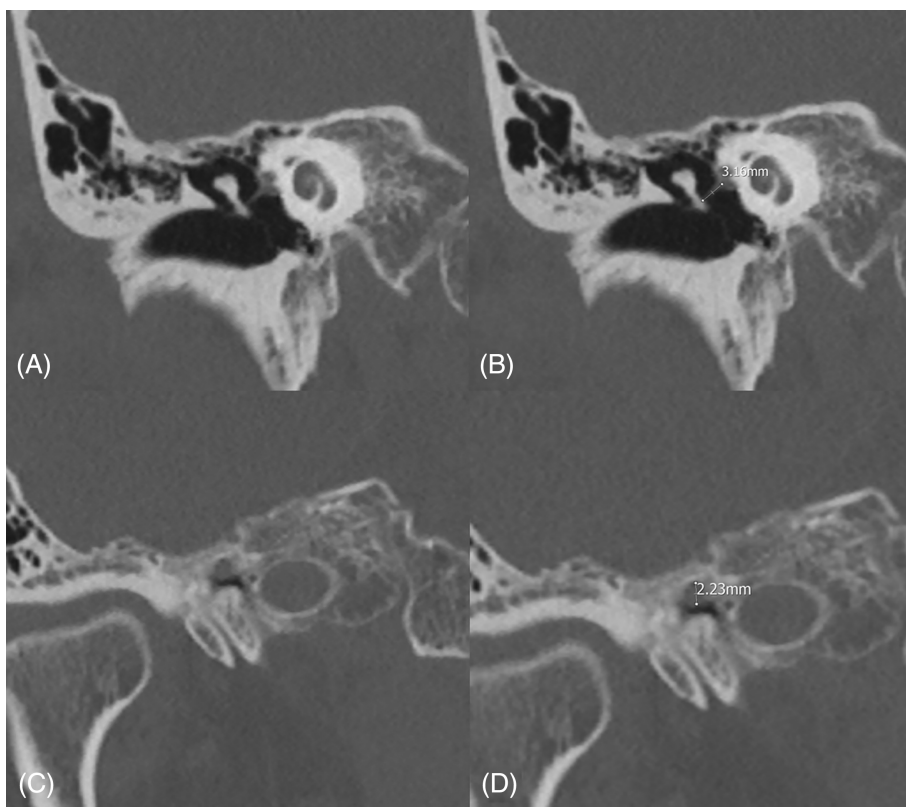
Tensor tympani measurement. Right temporal bone CT in coronal view. (A) The tensor tympani muscle was located using the cochleariform process and the malleus handle as anatomic landmarks. (B) Measurement of tensor tympani muscle length after the turn from the cochleariform process. (C) The tensor tympani muscle is located using the petrous part of the internal carotid artery as an anatomic landmark. (D) Measurement of the tensor tympani muscle width.
